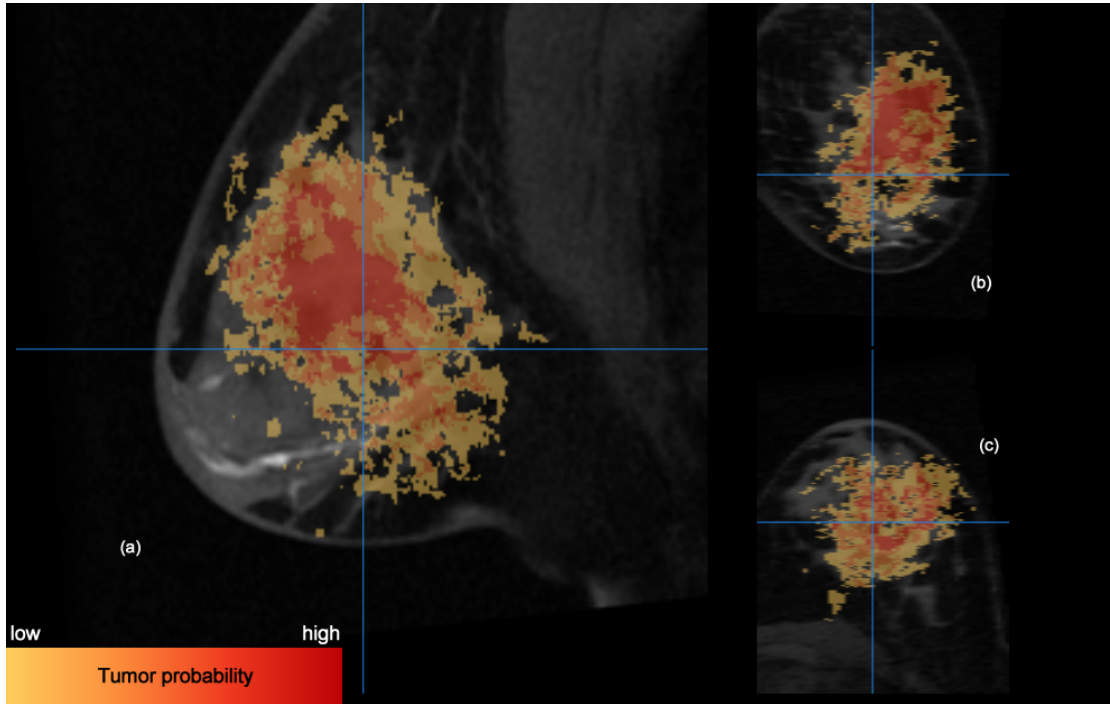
Example: Breast MRI scan with probability map, showing the sagittal view (a), the coronal view (b), and the axial view (c).
